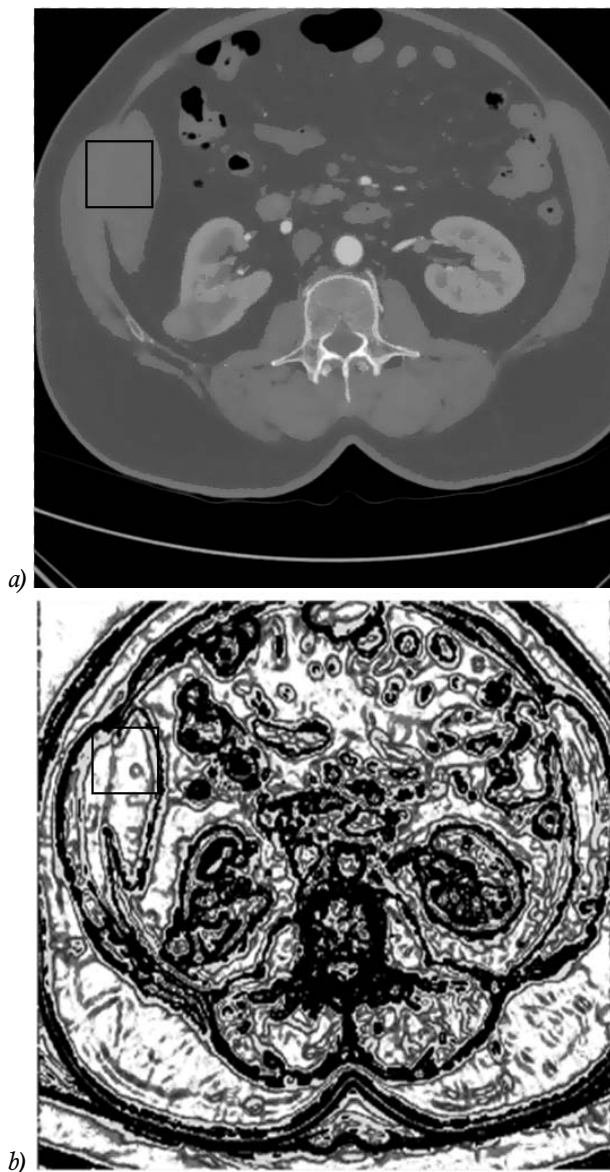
Result of work of the boundaries detector function $g(u)$: a) CT image after applying the anisotropic diffusion filter; b) display of the values of the function $g(u)$, the white areas correspond to homogeneous image areas, black areas - to the boundary regions between the segments
